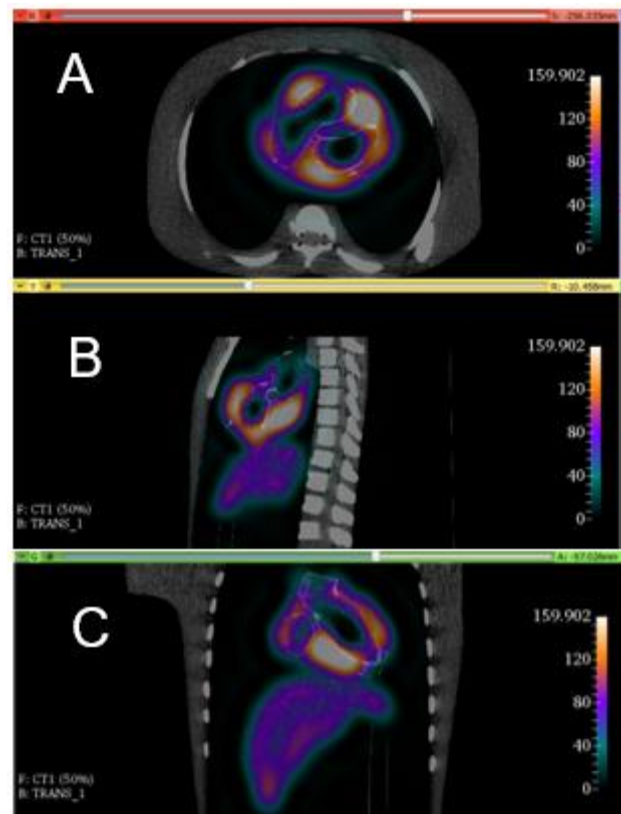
Example of alignment of SPECT images with the reference CT using the 3D Slicer software. (A) transverse plane, (B) sagittal plane and (C) coronal plane.
